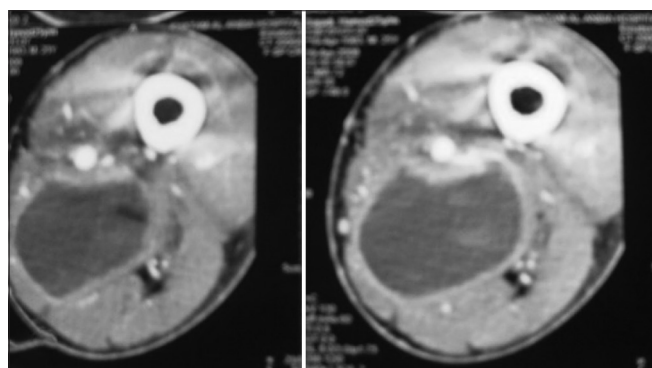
CT scan of the distal thigh shows a large mass compatible with the exact size of the aneurysm. The mass has two different compartments: An isointense mass at the periphery filled with old clot encompassing a hyperdense area which is the patent part of the aneurysm.
